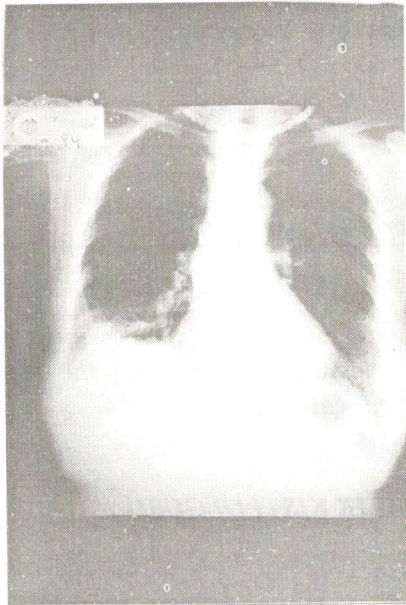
The chest radiography shows the inflammatory changes in the right lower lung due to complicated dome located hydatid cyst of the liver.
